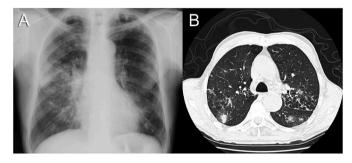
Patient 1 radiological findings. A: Chest radiograph (posteroanterior incidence) shows bilateral nodular opacities, more evident in the right middle lung field. B: Thorax CT scan shows bilateral ground-glass and consolidations (posterior segment of right upper lung lobe), centrilobular micronodules with *tree-in-bud* pattern (apicoposterior segment of left upper lung lobe).
